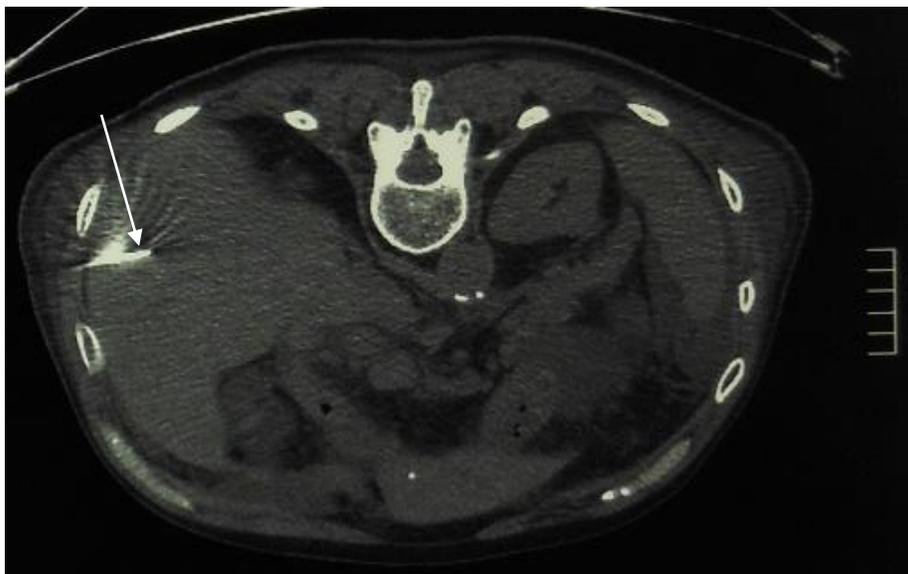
A CT scan-guided fine-needle cytology and core-needle biopsy (arrow) are on target.
